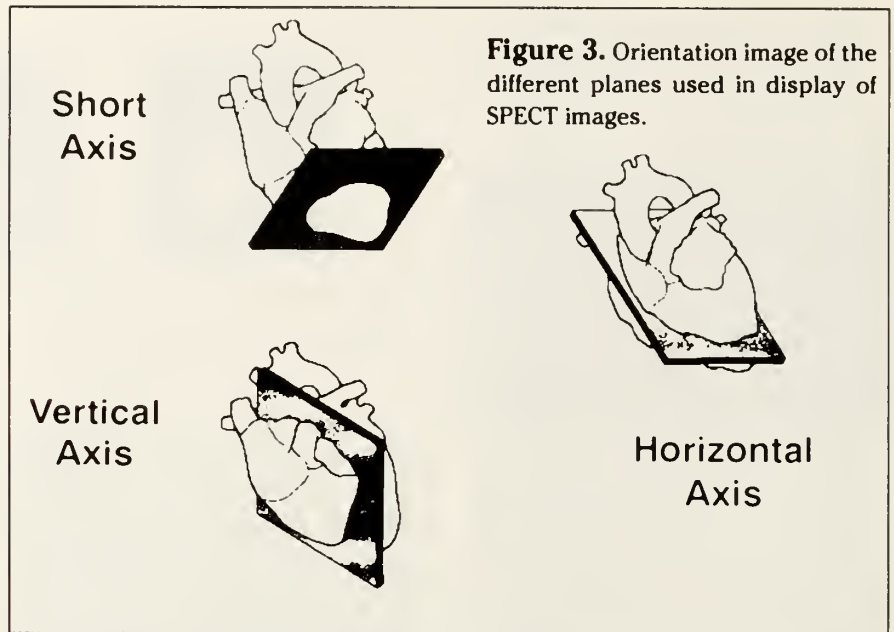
Orientation image of the different planes used in display of SPECT images.
